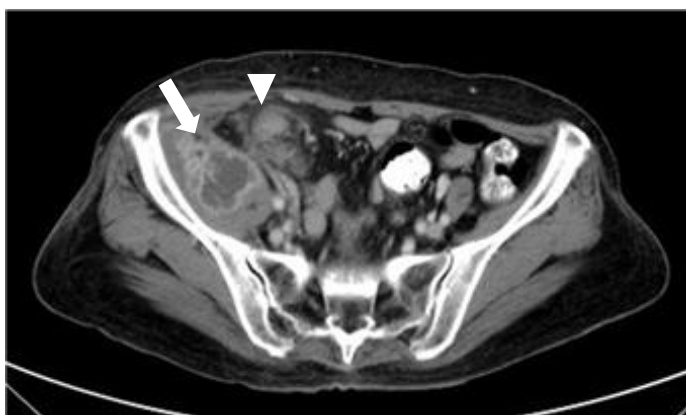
A 64-year-old female presented with right lower abdominal mass and fever. Axial abdominal CT scan demonstrated intraabdominal collection (arrow) and lymphadenopathies (arrow head). The final diagnosis was CA ascending colon.
